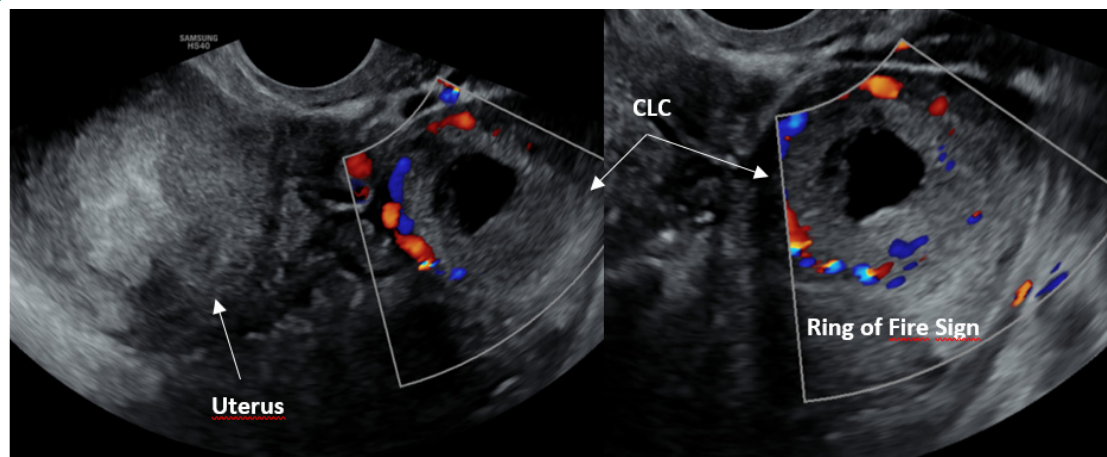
A 35-year-old pregnant female with a medical history of infertility of unknown cause presented at three weeks and three days of gestation, with several days of scant vaginal bleeding and mild pelvic pain. Initial physical exam was normal. Color flow Doppler ultrasound was ordered and revealed the pathognomonic “Ring of Fire” surrounding an Adnexal hypoechoic mass containing a cystic centered portion with peripheral neovascularization.
